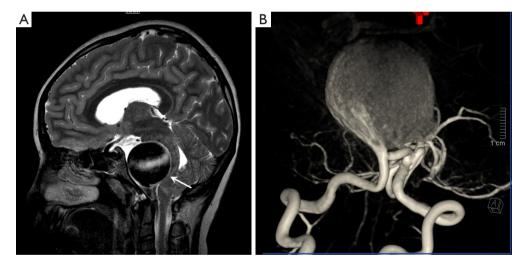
Brain magnetic resonance imaging showed a giant intracranial aneurysm. (A) Sagittal T2-weighted image showed a giant saccular aneurysm (4.0 cm  $\times$  3.9 cm  $\times$  3.9 cm in maximal anterior posterior, transverse and craniocaudal dimensions respectively) within the prepontine cisterns involving the basilar artery. There was significant compression of the ventral brainstem and fourth ventricle with posterior displacement. (B) 3D volume rendered reconstruction of the giant basilar intracranial aneurysm arising immediately distal to the vertebrobasilar junction.
